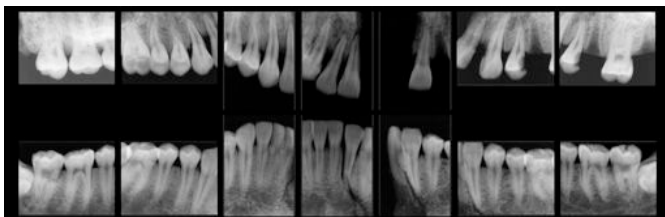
Periapical radiographs of maxillary and mandibular dentition excluding third molars.
